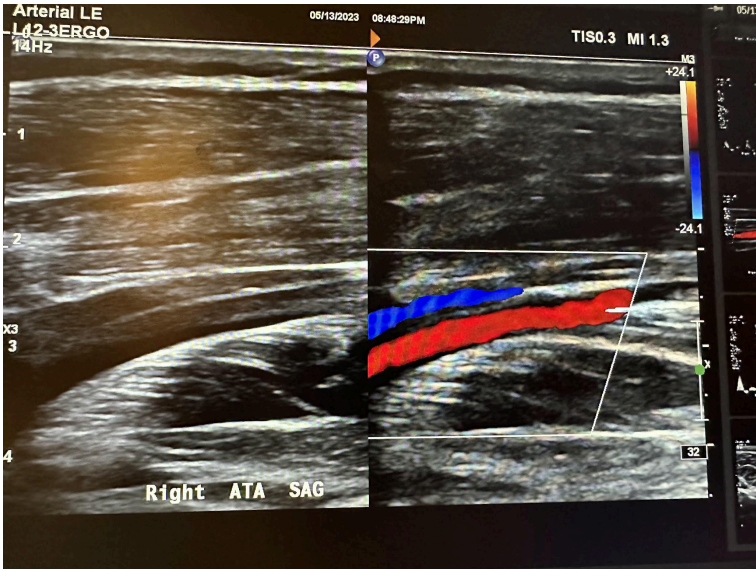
Side-by-side sagittal images of the right anterior tibial artery without color Doppler and with color Doppler.
